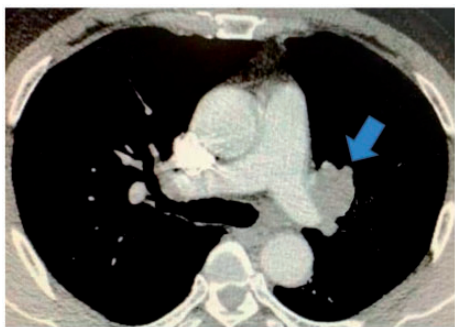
Chest computed tomography scan of a large T4 tumor with partial invasion of aortopulmonary window.
